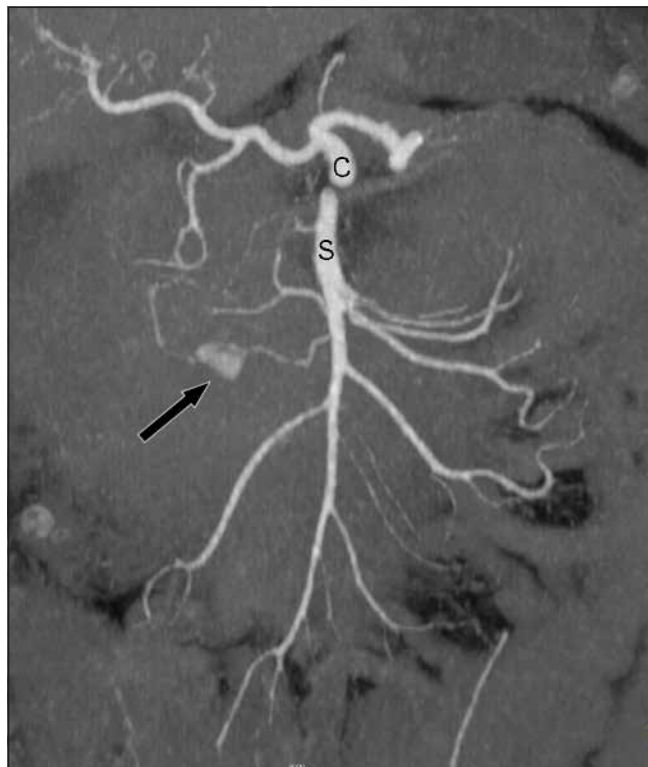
Coronal CT reconstruction showing the coeliac axis (C) and superior mesenteric artery (S); the aneurysm (arrow) arises from the inferior pancreaticoduodenal artery which is a branch of the superior mesenteric artery.
